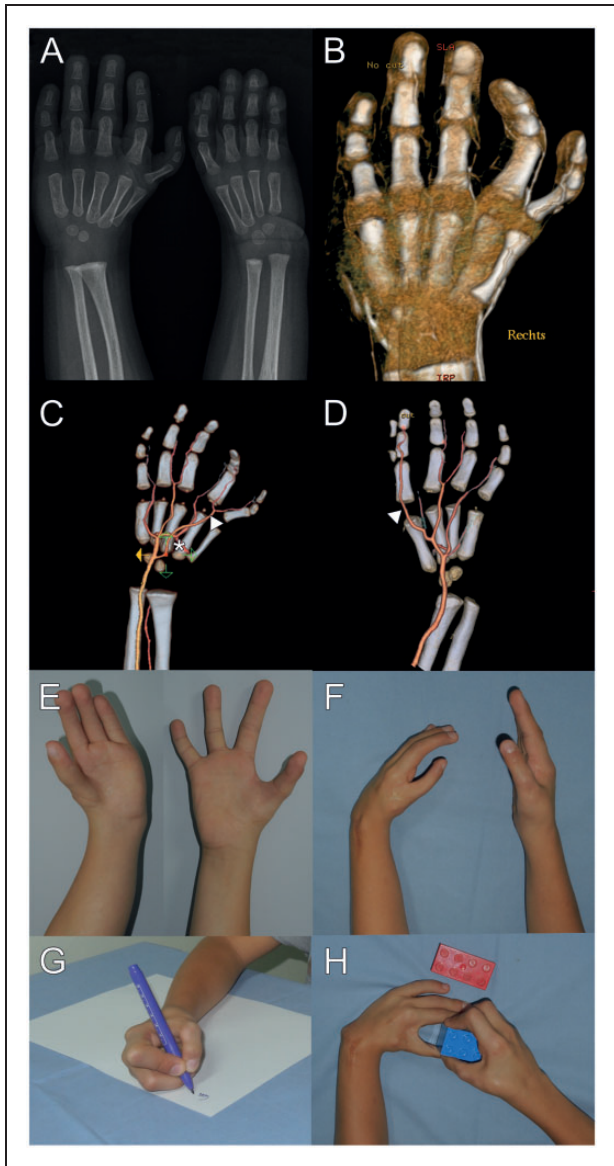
(a) The patient had Holt-Oram syndrome with bilateral radial clubhand Bayne and Klug Type I on the right, Type II on the left forearm. Radial ray deficiency showed a hypoplastic right thumb (Blauth Type 3 b), left thumb (Blauth Type 4). (b) X-rays showed a typical short radius on the right side and a hypoplastic radius with radial and palmar deviation of the carpus on the left forearm. (c) MDCT at age of 26 months showed that only the ulnar artery was present in both sides, leaving a deep palmar arch in the right (asterisk), but not the left hand (d). Bilaterally, a branch to the first and second digit was identified ((c and d), arrows). (e)–(h) The right side was corrected with pollicization of the second digit after resection of the hypoplastic thumb at the age of 28 months. Bilateral radial deviation was corrected by tendon transfer of flexor carpi radialis and extensor carpi radialis longus to the extensor carpi ulnaris and temporary K-wire transfixation. The hand and arm were functional 11 years after surgery.
